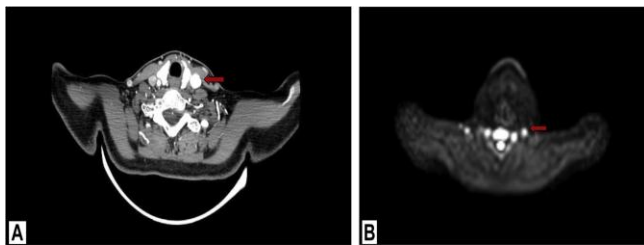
MSCTA (A) and DW MRI (B) images showing inflammation of the same arterial wall (red arrows)
